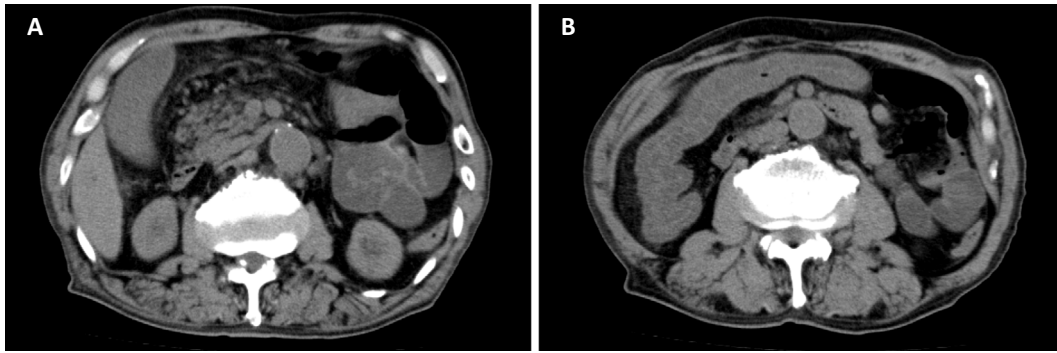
A, B: Abdominal computed tomography on admission revealed intestinal swelling and fluid collection, compatible with infectious enterocolitis.
